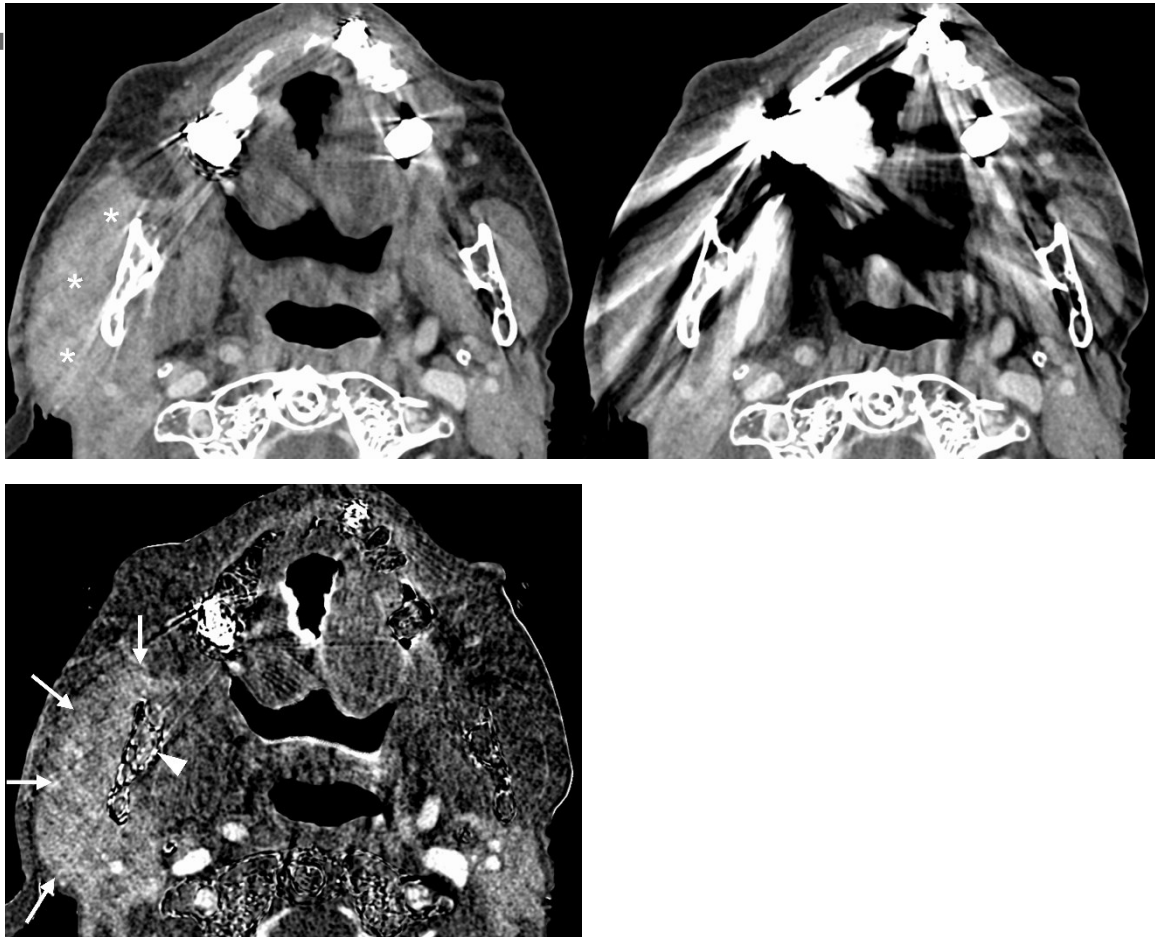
Female in her 90s with inflammatory spread to the masticator space from right mandibular osteomyelitis. On conventional contrast-enhanced CT (A), it is difficult to evaluate the right masticator space due to metal artifacts from dental hardware. Contrast-enhanced CT after the application of the metal artifact reduction algorithm (B) shows swelling of the right masseter muscle with mild, ill-defined enhancement (*). Subtraction iodine CT (non-enhanced CT subtracted from contrast-enhanced CT, C) shows not only
